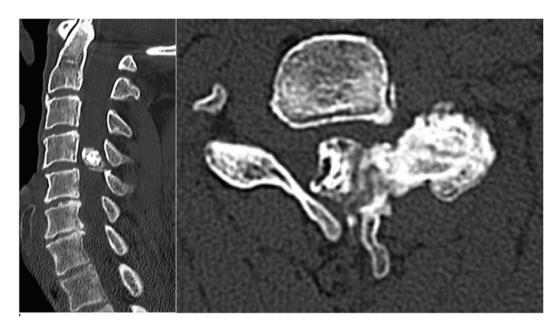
Showing pre-operative CT scans, sagittal and horizontal views of the cervical spine, progressive reduction of the spinal canal (more than 50 %), and raised bony structure involving both lamina and vertebral joint on the left side.
